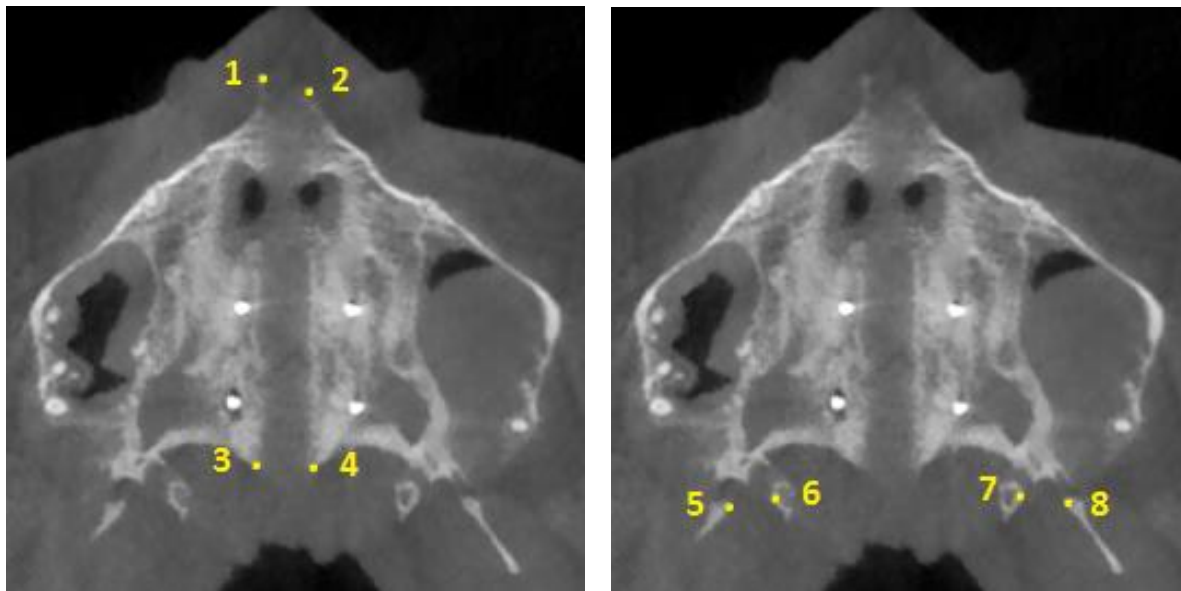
Landmarks identified in the axial palatal section (APS) for the post-expansion CBCT. A: Landmarks in the midpalatal suture. B: Landmarks in the pterygoid processes of the sphenoid bone. 1: Right anterior nasal spine (Rt ANS); 2: Left anterior nasal spine (Lt ANS); 3: Right posterior nasal spine (Rt PNS); 4: Left posterior nasal spine (Lt PNS); 5: Most medial point of the lateral plate of the right pterygoid process (Rt Lat Pter); 6: Most lateral point of the medial plate of the right pterygoid process (Rt Med Pter); 7: Most lateral point of the medial plate of the left pterygoid process (Lt Med Pter); 8: Most medial point of the lateral plate of the left pterygoid process (Lt Lat Pter).
